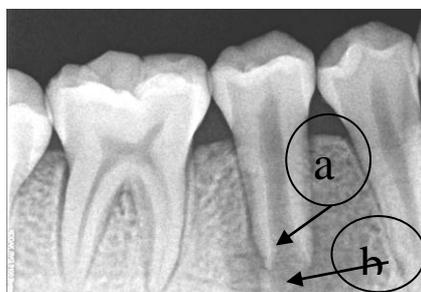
35 presented with incomplete root formation and wide open apex (a). A Large periapical lesion in relation to 45 is also evident (b).
